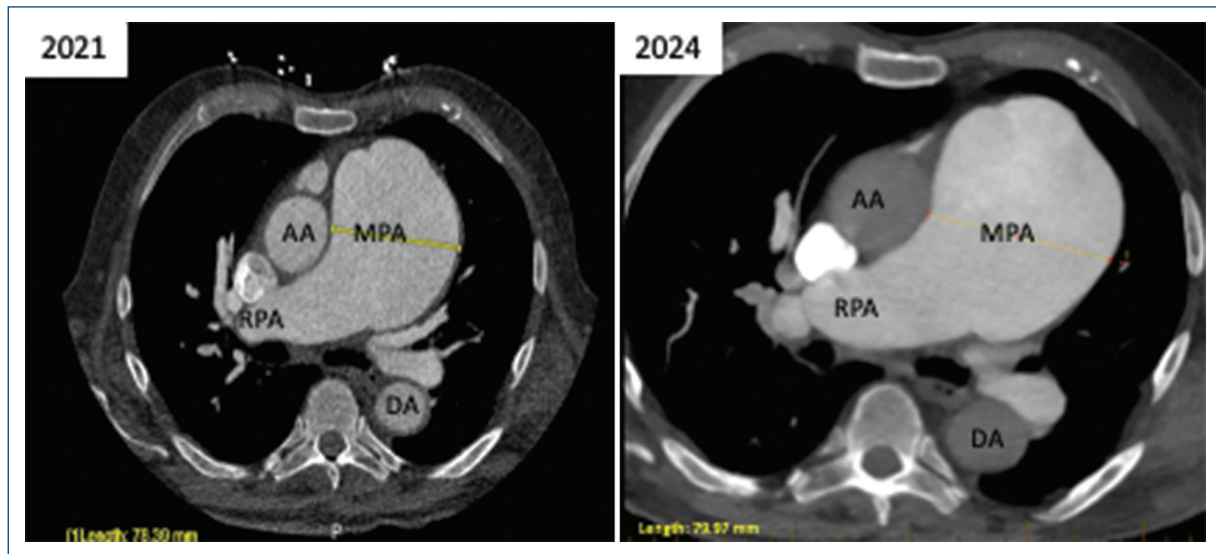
Axial CT images showing the maximum dimension of the pulmonary artery aneurysm in 2021 and 2024, demonstrating overall stability since 2021. CT: computed tomography; AA: ascending aorta; DA: descending aorta; MPA: main pulmonary artery; RPA: right pulmonary artery.
